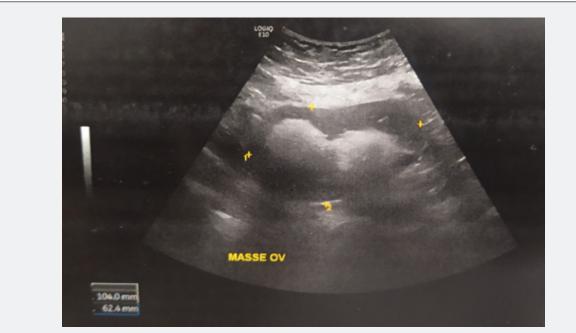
Ultrasound image of a right ovarian mass Complemented by a pelvic MRI which showed a right ovarian lesion of organic germinal nature related to a mature cystic teratoma, without any atypical sign.
